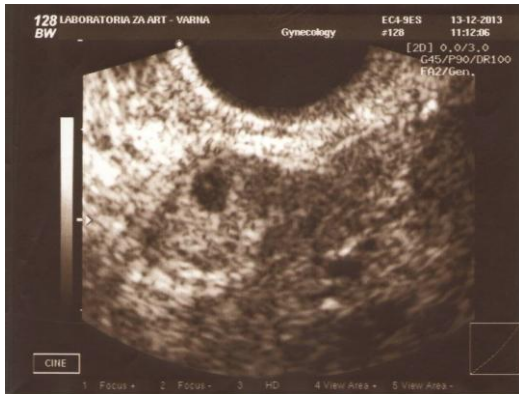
Ultrasound visualization of ectopic gestational sac
